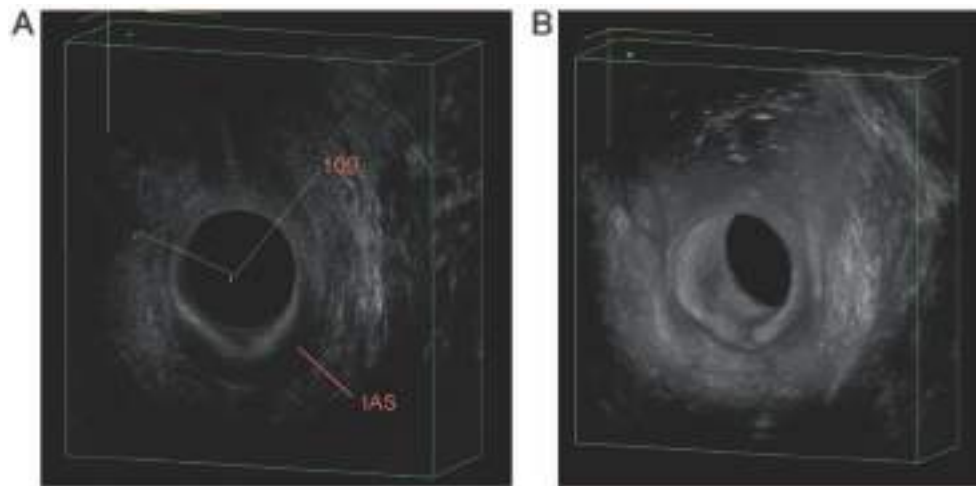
(a) Endoanal ultrasound revealing combined external sphincter defect (measuring 109°) with significant retraction of the internal sphincter (IAS). (b) The external sphincter defect can be more easily appreciated on 3D rendered imaging.
